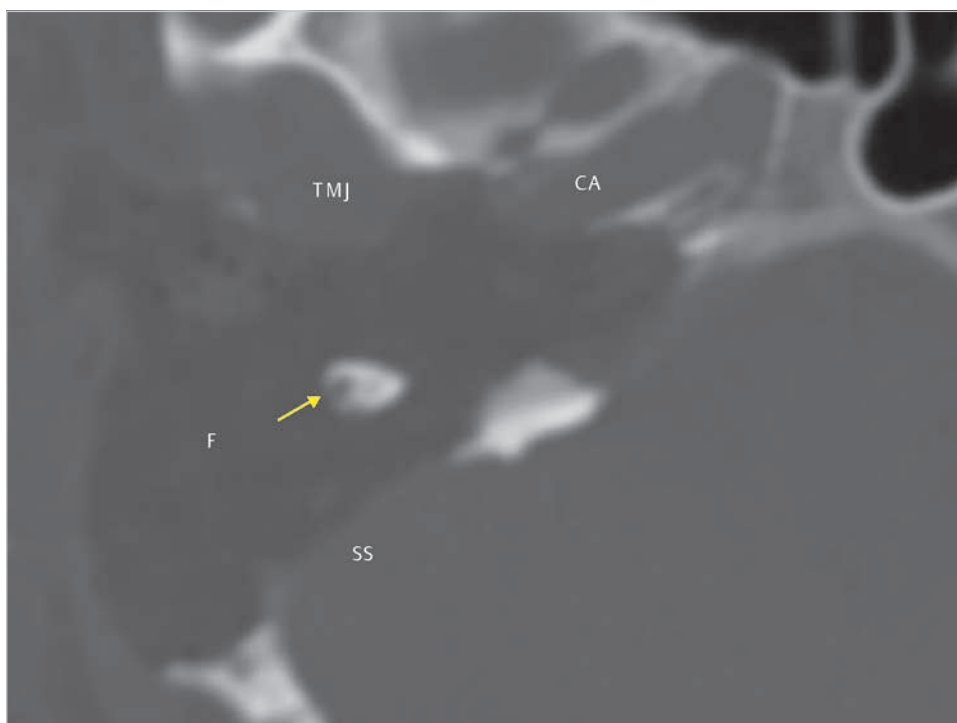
The postoperative CT shows extensive removal of bone from the petrous apex, exposing the posterolateral face of the carotid artery and the posterior face of the temporomandibular joint. The facial nerve running in the fallopian canal is seen (arrow). CA, carotid artery; F, abdominal fat; SS, sigmoid sinus; TMJ, temporomandibular joint.
